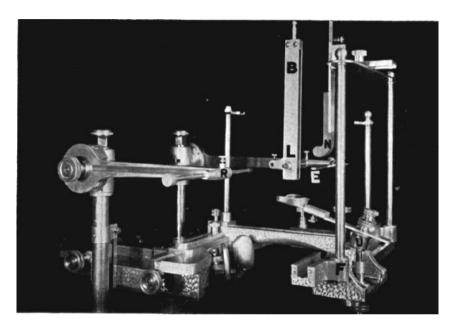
The Broadbent Head Holder for roentgenographic studies of the living head. Built in the Anatomical Laboratory Western Reserve University for the Bolton Study of the development of the face of the growing child.
